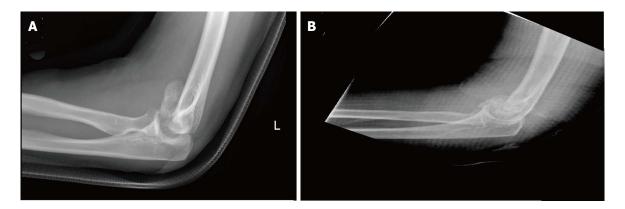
Lateral elbow X-ray of a two patients with distal humeral coronal shear fractures. A: Distal humeral coronal shear fracture-lateral view; B: The double-arc sign is seen, which signifies a McKee's type IV fracture in the Bryan and Morrey classification (involvement of both the capitellum and trochlea).
